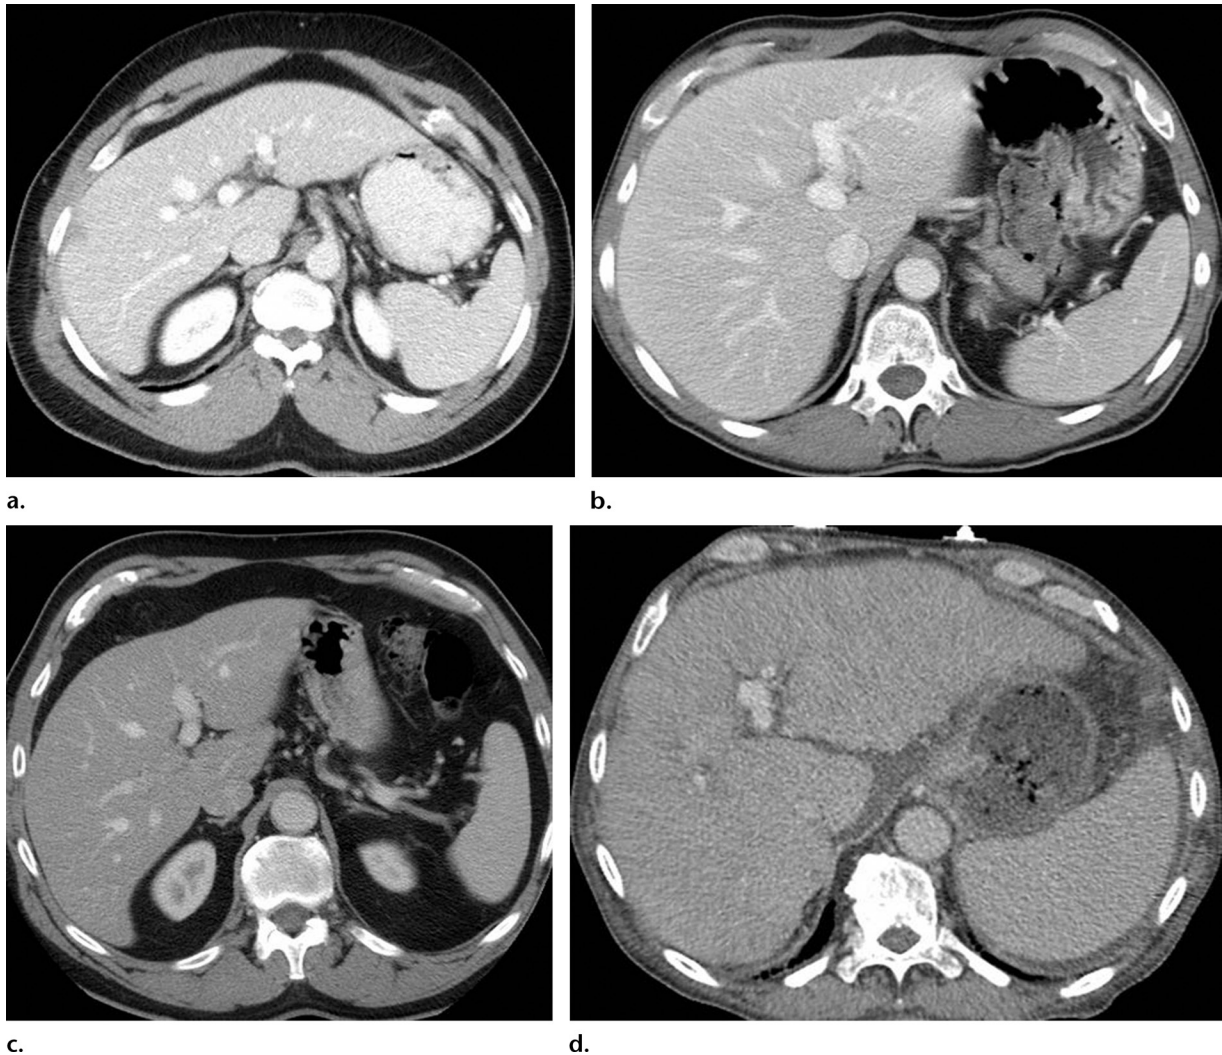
Axial contrast-enhanced CT images of four patients in whom liver biopsy demonstrated varying degrees of hepatic fibrosis. (a, b) Stage I (a) and stage II (b) fibrosis in patients with hepatitis C. (c) Stage III fibrosis in a patient with nonalcoholic fatty liver disease. (d) Stage IV fibrosis in a patient with liver disease related to both hepatitis C and alcohol use. While these livers become visually a little more heterogeneous, particularly in stage IV, CTTA is able to demonstrate subtle differences in heterogeneity and aid in stratifying the presence and severity of fibrosis (13,74).
